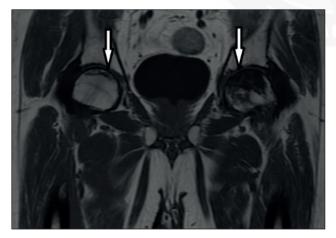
Coronal T1-weighted MRI of bilateral femoral heads.
